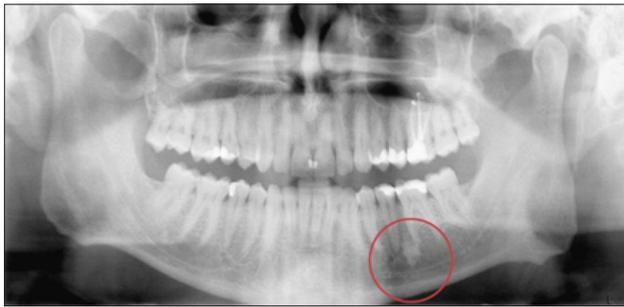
Panoramic x-ray of a 27 years old man with radiological finding periapical between teeth 35 and 36 (Case 2).
